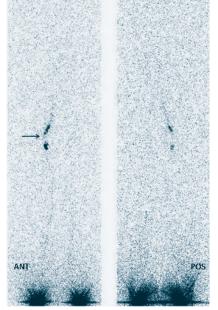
Abnormal 20min lymphoscintigram of a patient with left lower extremity lymphoedema. Note visualization of the inguinal lymph nodes only on the unaffected side (arrow).
